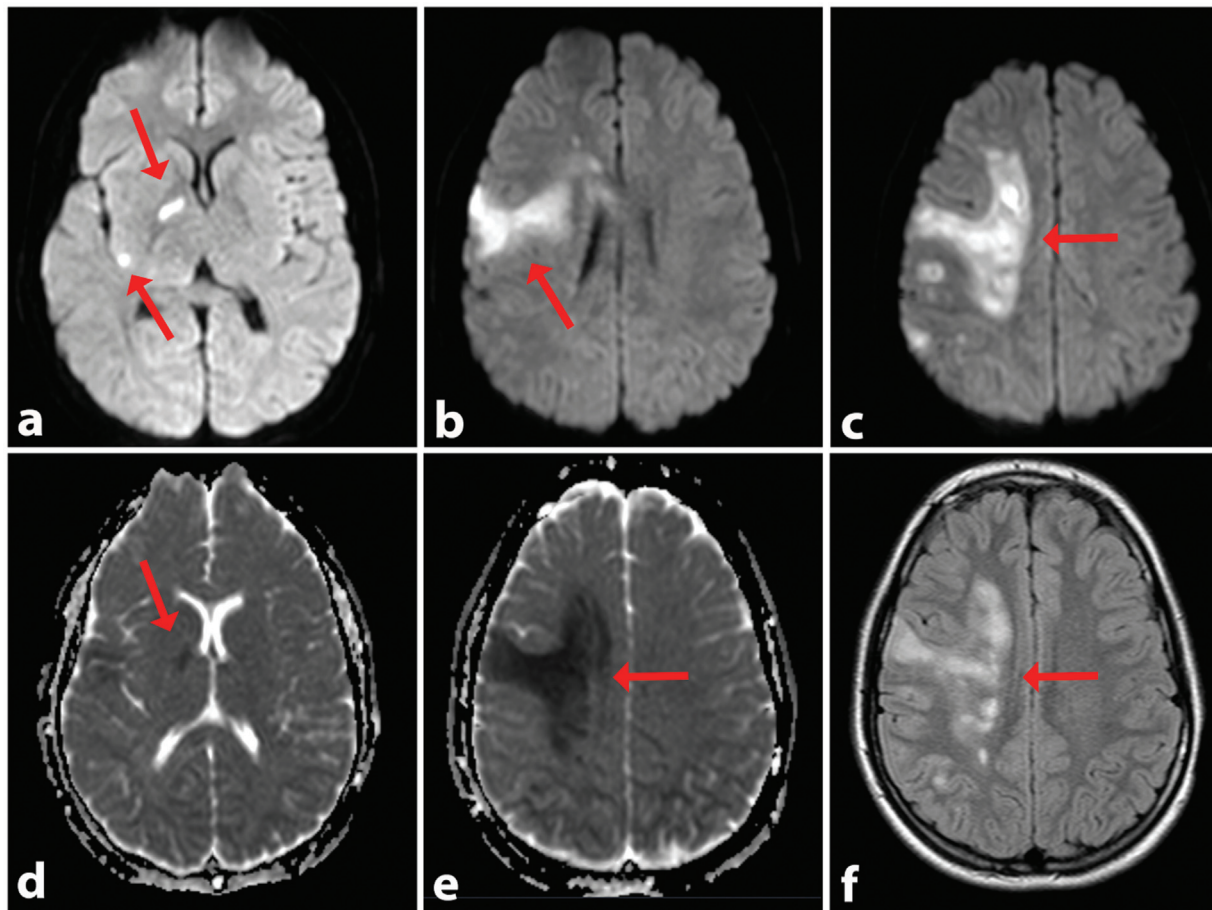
Magnetic resonance imaging performed on the eighth day. All figures are on the axial plane. (a,b,c) Diffusion-weighted imaging showing hyperintense areas on the right middle cerebral artery vascular territory, suggestive of acute ischemia (red arrows). (d,e) Apparent diffusion coefficient map imaging showing hypointense signal on the middle cerebral artery vascular territory (red arrows), confirming the suspicion of acute ischemia. (f) Fluid attenuation inversion recovery sequence, evidencing perilesional edema in the ischemic territory (red arrows).
